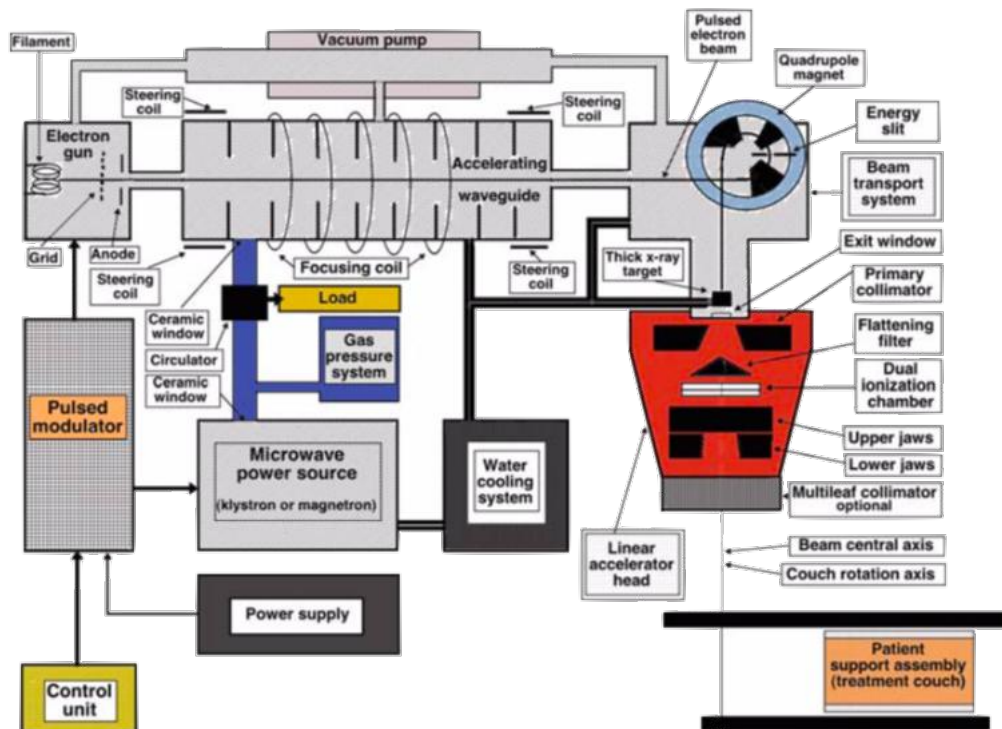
Design configurations for isocentric medical LINACs working in photon mode. The accelerating waveguide is in the gantry parallel to the isocenter axis; electrons are brought to the movable target through a beam transport system; the RF-power generator is located in the gantry stand; the machine produce megavoltage X-rays.
